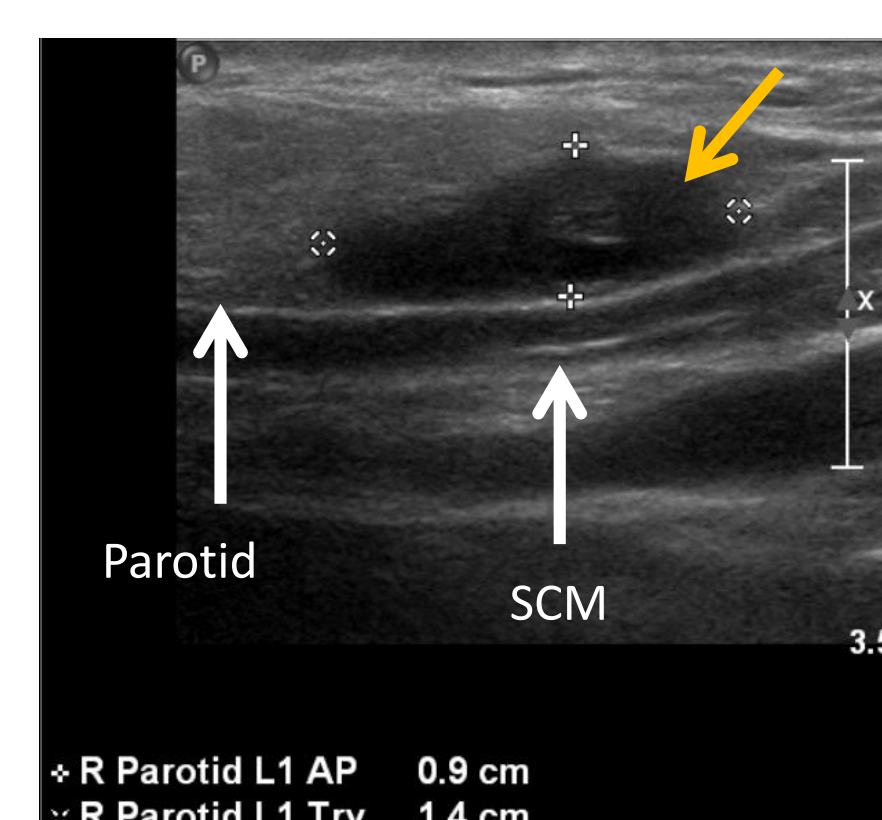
Ultrasound of right neck lesion
